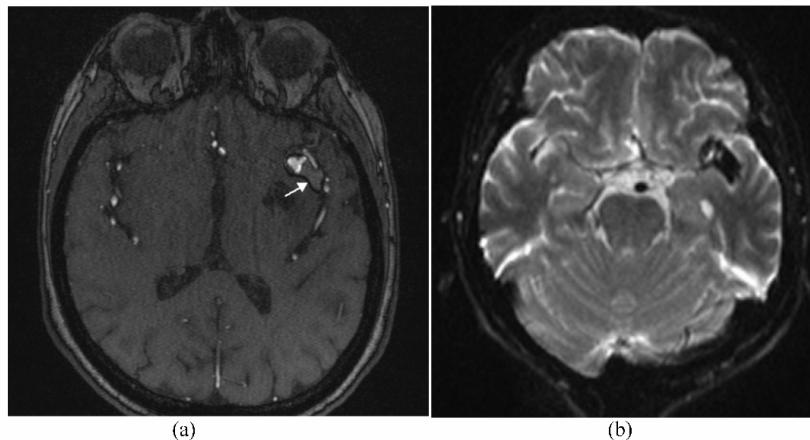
(a)-Intracranial lipoma demonstrating high signal intensity on Time-of-Flight (ToF) MR angiography sequence due to associated T1 shortening, a feature also shared by subacute haematomas. Dark margin posteriorly around the lipoma is due to chemical shift artifact (arrow). (b) – b0 sequence diffuse weighted image (DWI) shows lipoma as low signal due to fat suppression in these sequences. Several blood products can show low signal on these images due to susceptibility effects and these can also cause difficulty in differentiation
